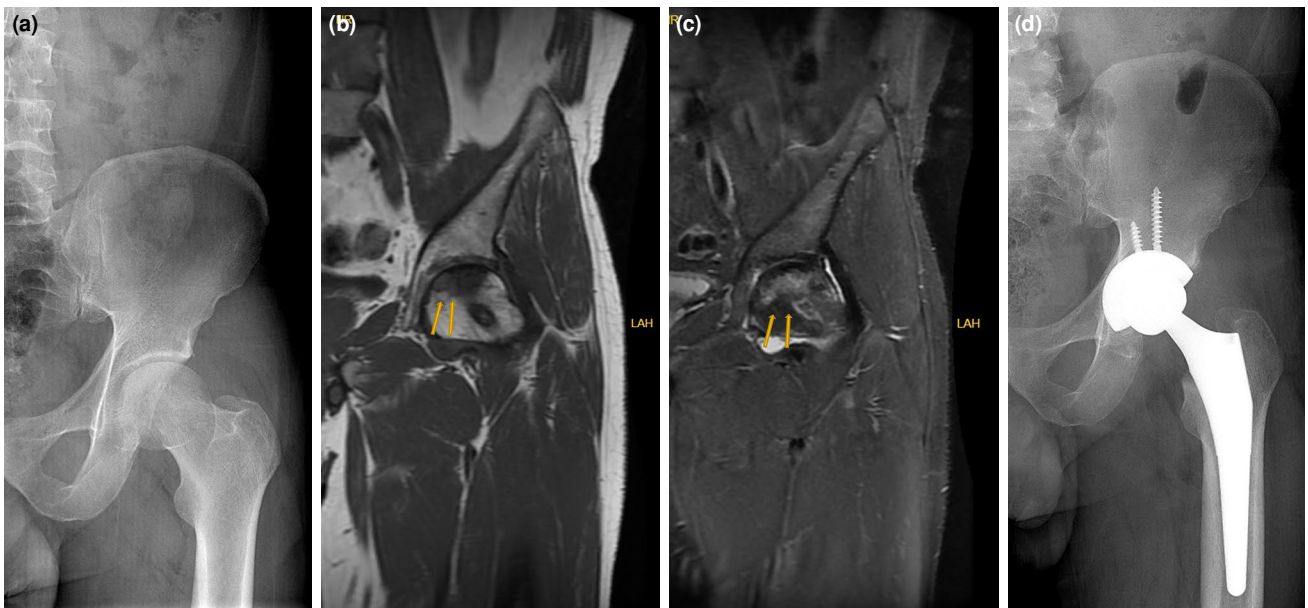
(a) Radiological analysis of a 38-years-old female patient with normal X-ray views. (b, c) After a failed bilateral core decompression procedure and constant pain, the osteonecrotic lesion did not resolve and (d) the patient was eventually treated with a hip replacement.
